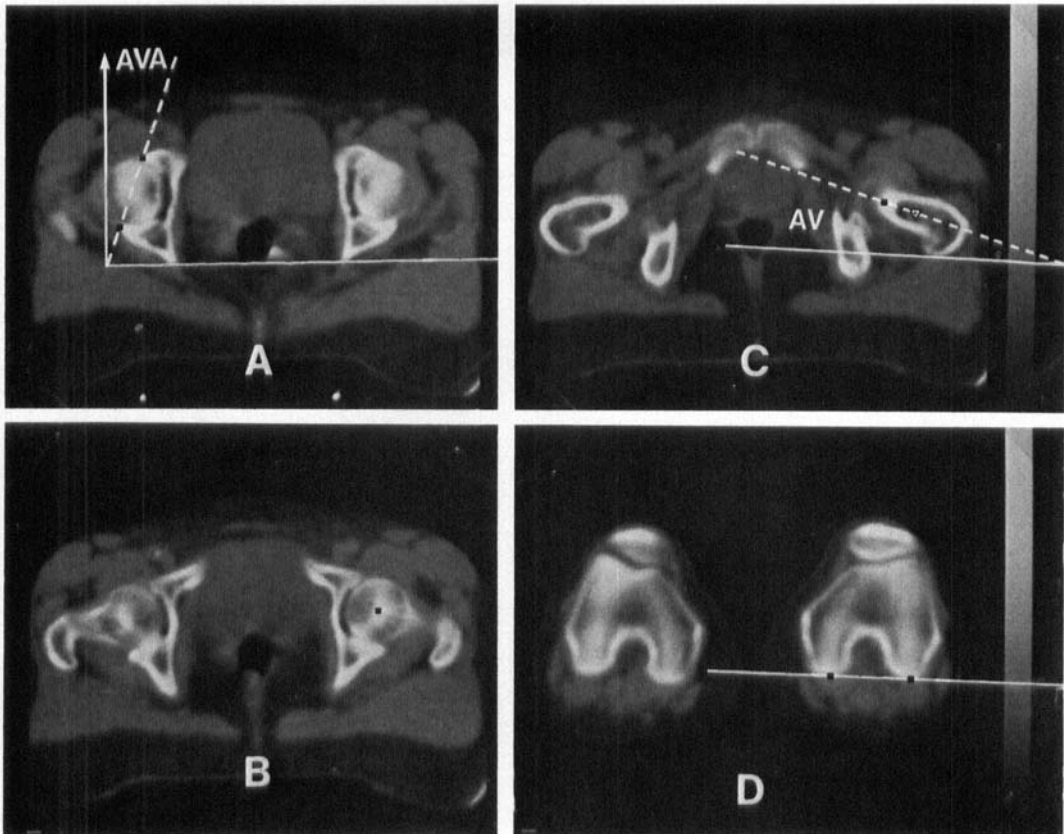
Computed tomograms viewed from below for determination of the anteversion of the acetabulum and of the femoral neck. A. Tomogram through the centres of the acetabulum. A measuring point is set at the anterior and at the posterior edge of the right acetabulum. The anteversion of the acetabulum (AVA) is determined as the angle between the line connecting these points (---) and the plane sagittal to the pelvis (→). B. Tomogram of the femoral heads. A measuring point is set in the centre of the left femoral head and projected on to image C, which is a section through the middle part of the femoral necks. A second measuring point (∇) is set centrally in the left femoral neck, and the anteversion of the femoral neck (AV) is constructed as the angle between the line connecting these points (---) and the reference plane (—). D. The reference plane is determined as the dorsal tangent (—) of the scanned femoral condyles.
